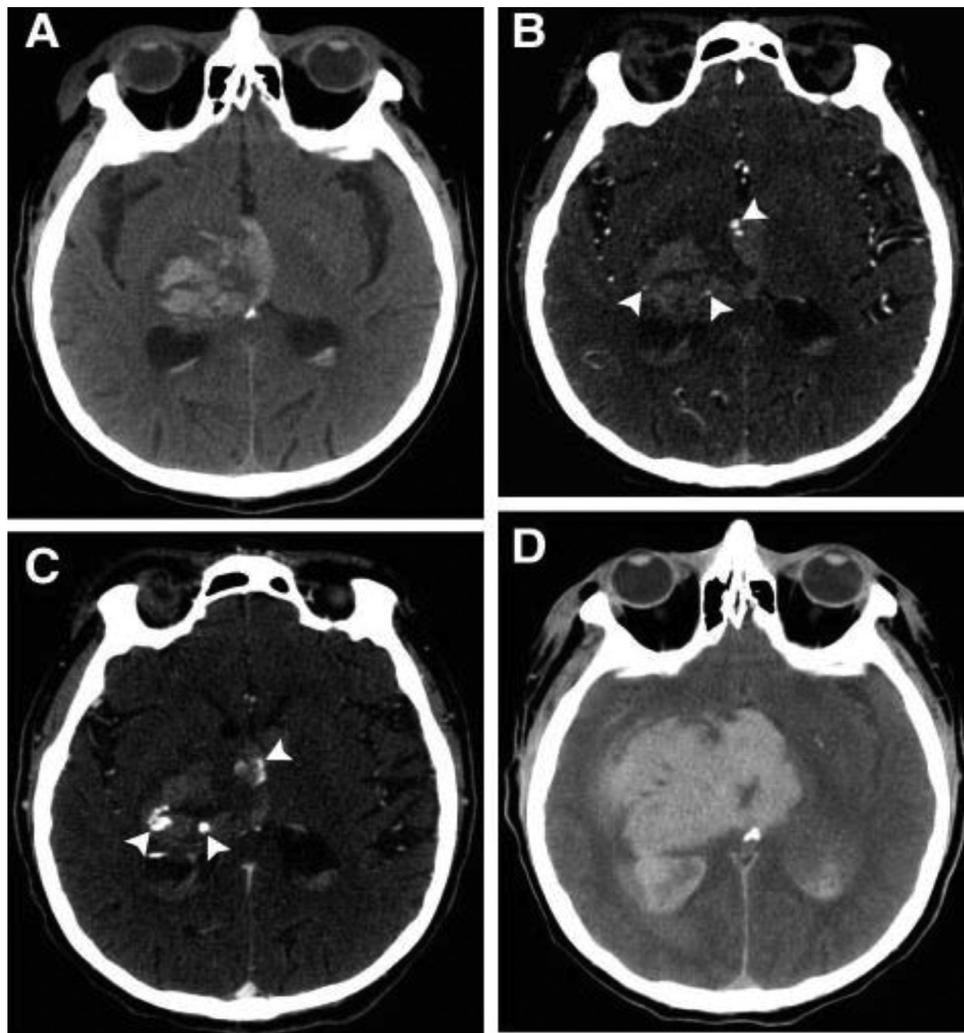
A 67-year-old man on warfarin therapy for atrial fibrillation, also he was on daily aspirin intake presented with sudden syncope followed by prolonged coma (INR on admission was 2.7). (A) Non-enhanced CT demonstrates a right thalamic intracranial hematoma “ICH” (24 mL) with mild contralateral midline shift, and associated intraventricular hemorrhage “IVH”. (B) Axial CTA source image in spot windows demonstrates 3 foci of contrast pooling within the ICH (arrowheads), consistent with spot signs. The largest spot sign measures 10 mm in maximum axial dimension. (C) Delayed CTA acquisition 48 seconds after the first-pass CTA shows that the spot signs increased in volume and changed in morphology (arrowheads). (D) NCCT 8 hours after the baseline CTA demonstrates marked interval expansion of both the ICH (94 mL) and IVH. The patient died shortly after the follow-up NCCT.
